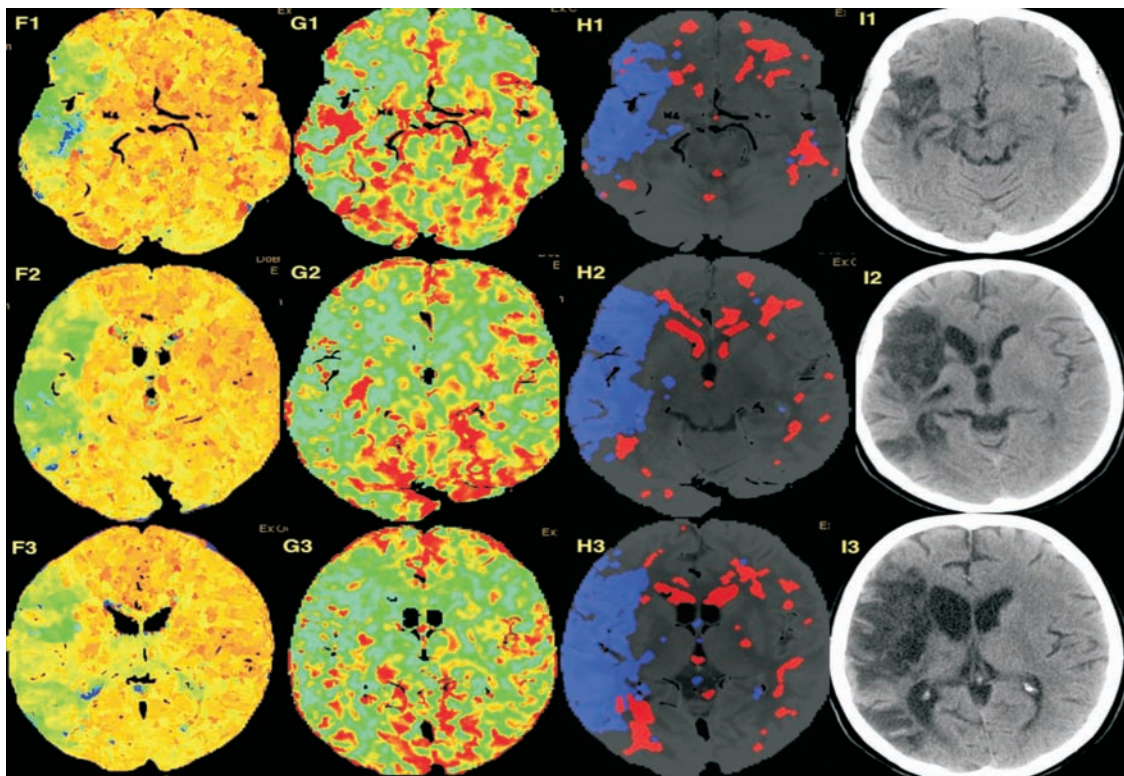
The same patient. F, G, H – continuation of PCT investigation. F1, 2, 3 – TTP map. G1, 2, 3 – PS map. H1, 2, 3 – automatic Tissue Classification map, blue zones correspond the irreversible infarcted tissue, red zones correspond to “penumbra”. I1, 2, 3 – non contrast CT follow-up investigation after 6 months, chronic stage of ischemic stroke, massive cystic-gliotic changes in the right middle cerebral artery vascularization territory with retraction of the right lateral ventricle.
